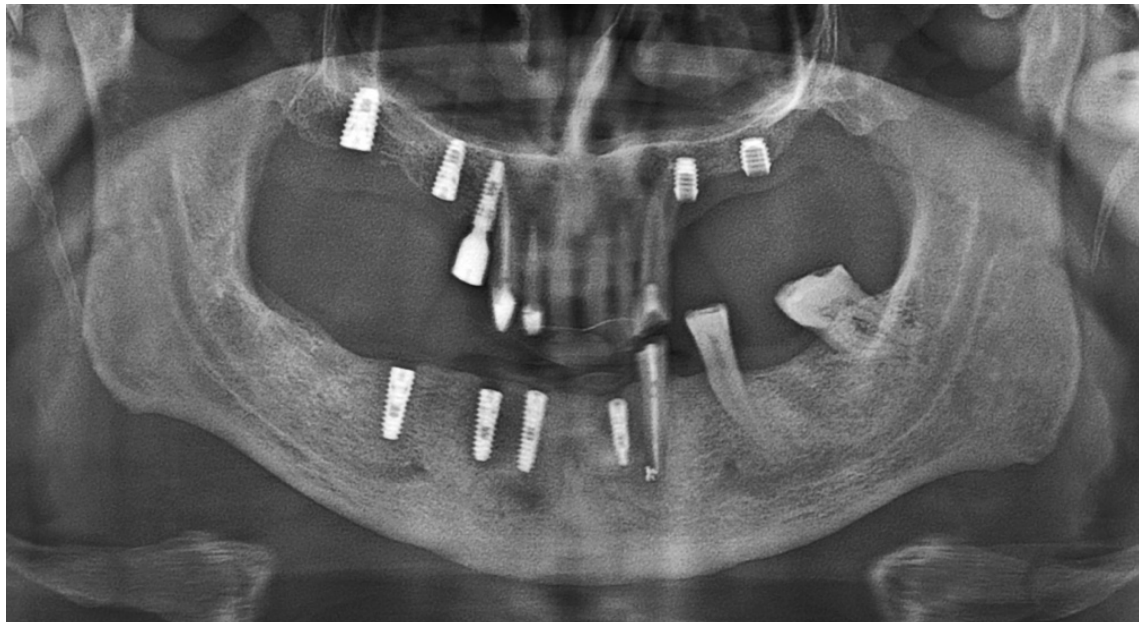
Postoperative panoramic radiograph at 1 week following reimplantation of implant 24.
